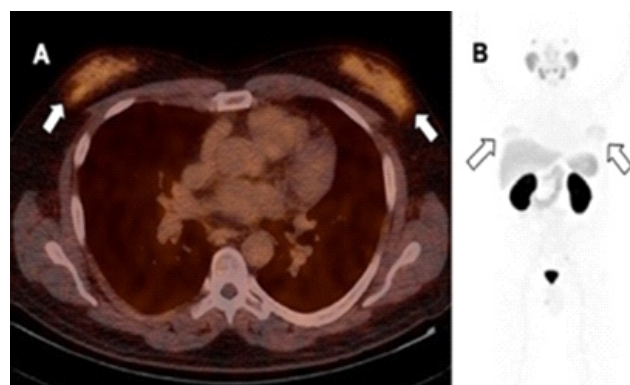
Gallium-68 PSMA PET/CT in a gynecomastia demonstrates increased PSMA uptake, related to antiandrogen therapy for prostate cancer [46].
